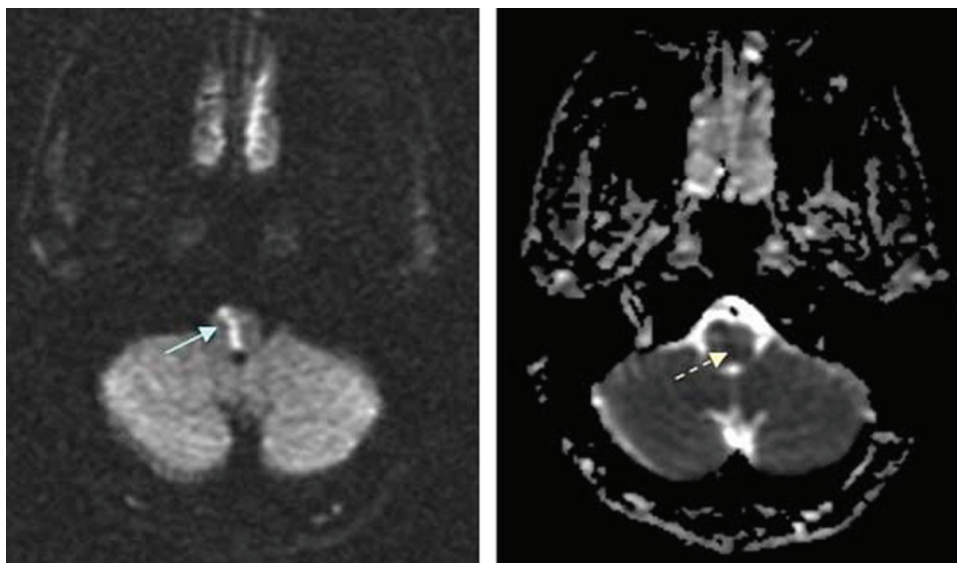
MRI – DWI and ADC images; solid arrow – acute brainstem infarct; dashed arrow – confirming acute infarct.
